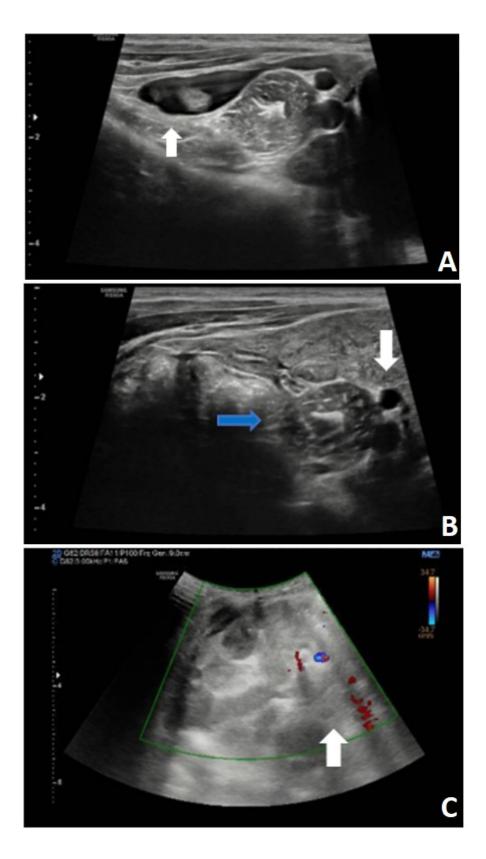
Abdominal ultrasonography. (A) The arrow indicates the fluid layer in the parieto-colic gutter with thickening and hyperechogenicity of the locoregional adipose tissue. (B) The 'blue arrow' points at a small bowel loop and traction aspect to the right of the meso in the para-umbilical region, while the 'white arrow' indicates multiple lymph nodes increased in size. (C) The arrow indicates poor sampling of the vascular signals of the mesenteric fan in abdominal ultrasonography.
